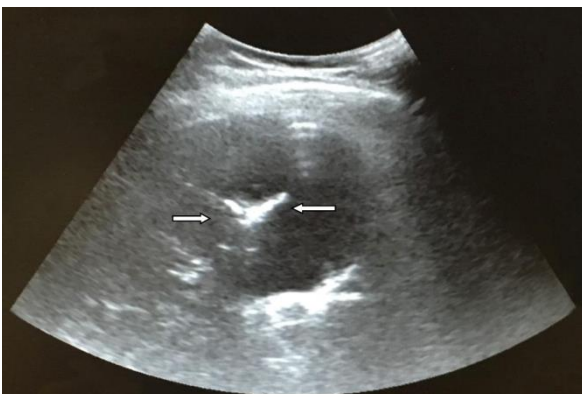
The image of the pneumobilia on the ultrasound of the patient
